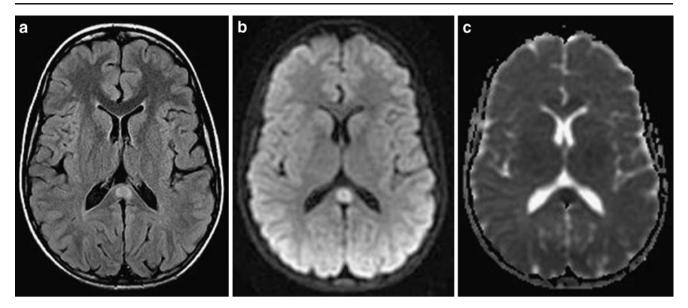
MR image at onset of symptoms. Axial FLAIR image (a), axial diffusion-weighted image (b), and ADC map (c) reveal a hyperintense lesion in the central splenium that shows restricted diffusion
